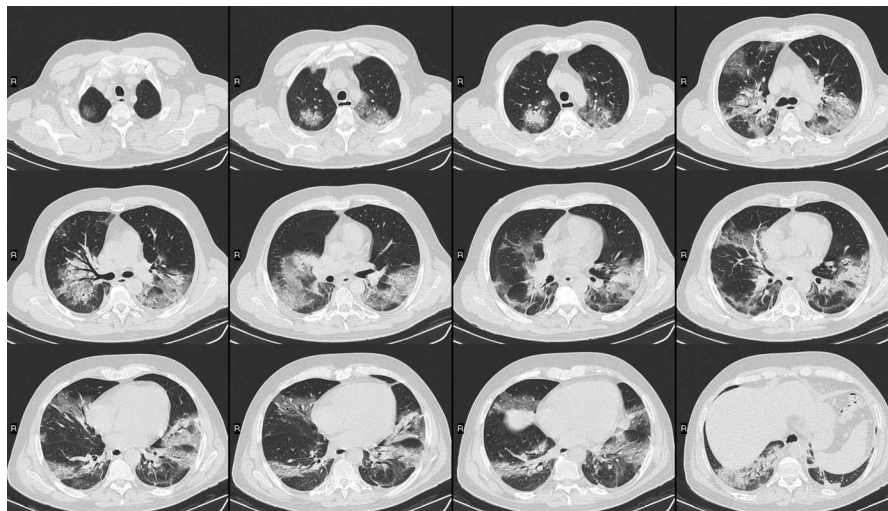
Soon after, the patient developed fever, cough, and intense dyspnea. On April 4, he went to a local accident and emergency department, where a chest CT was performed: axial images showed widespread multiple bilateral GGOs and consolidations with air bronchogram in both upper and lower lung fields with predominant peripheral distribution, concordant with typical bilateral COVID-19 pneumonia.^{2,3} After several days of assisted ventilation with continuative positive airway pressure and multidrug treatment (including steroids, hydroxychloroquine, tocilizumab, levofloxacin, azithromycin, low-molecular-weight heparin, antiplatelet, lopinavir/ritonavir), patient's disease status improved. To the best of our knowledge, this is the first reported case of an atypical presentation of a confirmed COVID-19 pneumonia as unilateral isolated and relatively small ¹⁸F-FDG-avid consolidation in an asymptomatic oncological patient incidentally detected at PET/CT. Growing literature reports on symptomatic and asymptomatic⁴⁻¹⁸ oncological patients with incidental ¹⁸F-FDG-avid pulmonary findings highly suggestive of COVID-19, although presenting with more common multiple bilateral GGOs and consolidations. Our case highlighted that atypical PET/CT presentation of COVID-19 in asymptomatic oncological patients, appearing as in our case, is the most challenging issue for nuclear medicine physicians. Indeed, oncological patients undergoing PET/CT may present with pulmonary malignancies (eg, lung cancer, lymphoma), but often copresenting pulmonary treatment-related inflammatory/infective processes (eg, nonspecific pneumonia). At PET/CT, these conditions could show similar morphofunctional appearance, but considered atypical for COVID-19. Therefore, in such unexpected COVID-19 case, to suspect the most likely diagnosis, although incorrect, is highly probable. Now more than ever, it is of paramount importance to avoid delay in COVID-19 diagnosis. Consequently, we should consider any new-onset pulmonary lesion as a possible COVID-19 manifestation, until proven otherwise. Therefore, a SARS-CoV-2 test may be considered even for an asymptomatic patient at low risk of SARS-CoV-2 infection and presenting with an apparently "far-from-COVID-19" finding at ¹⁸F-FDG PET/CT, aiming to promptly reach a definitive diagnosis, reduce the viral spread, and early indicate appropriate therapeutic management.
